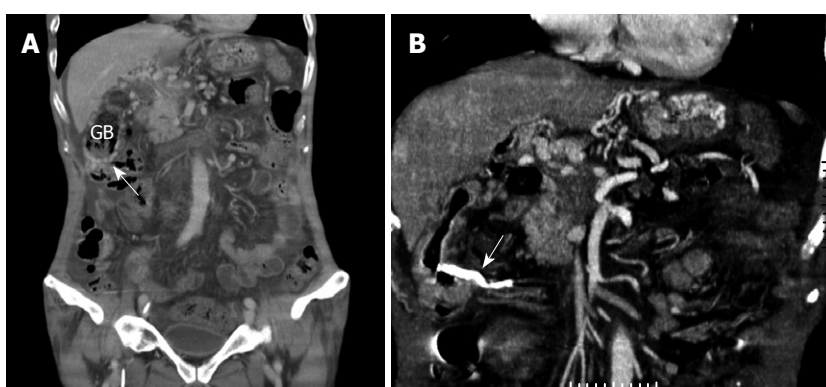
Abdominal computed tomography. A: Prominent vessels (arrow) formed around the gall bladder; B: Obliterated varicose vein (arrow).
